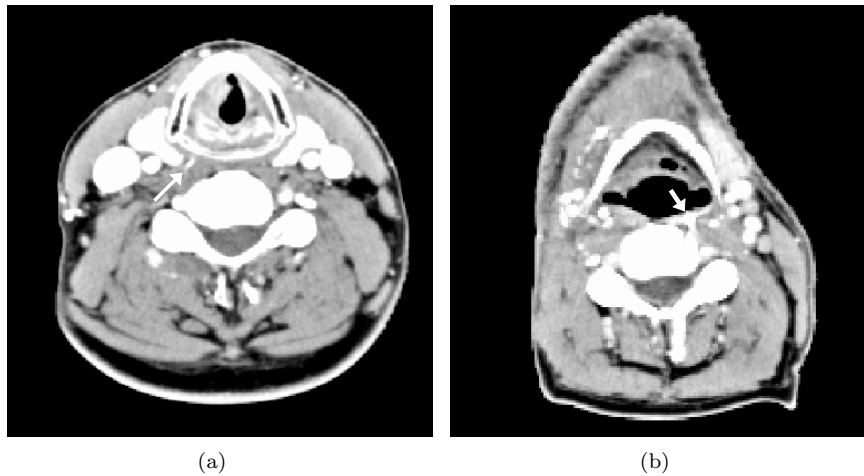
A transversal slice of CT scan of two patients with implanted gold markers. For one patient the marker is located in deep muscle compartments (a). For an other patient the marker is located superficially (b). In order to prevent artifacts, the transversal slices are shown imaging the tip of the markers.
